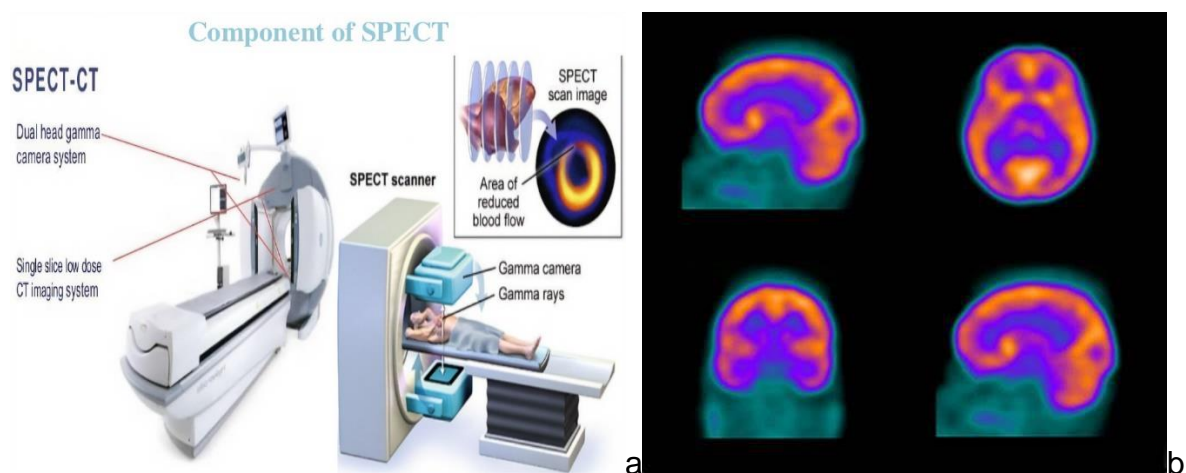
a) Components of SPECT. b) Image taken with the SPECT technique
